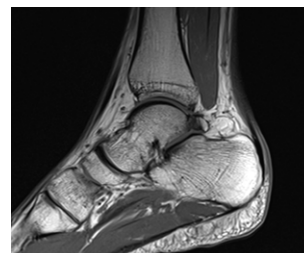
MRI of the left ankle showing a small bony fragment posterior to the talus along with low signal areas on T1.
